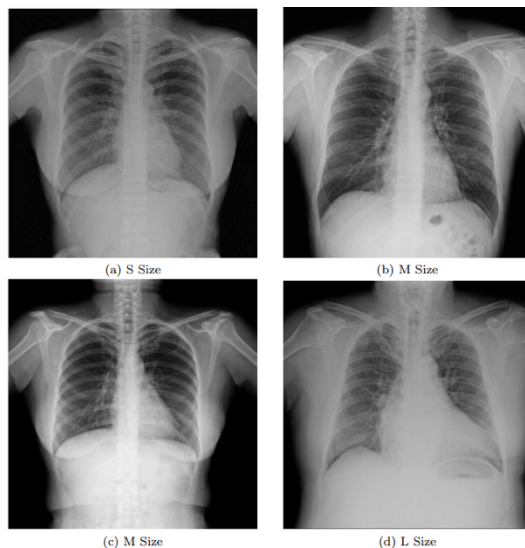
Example of chest X-ray images on volunteers.
